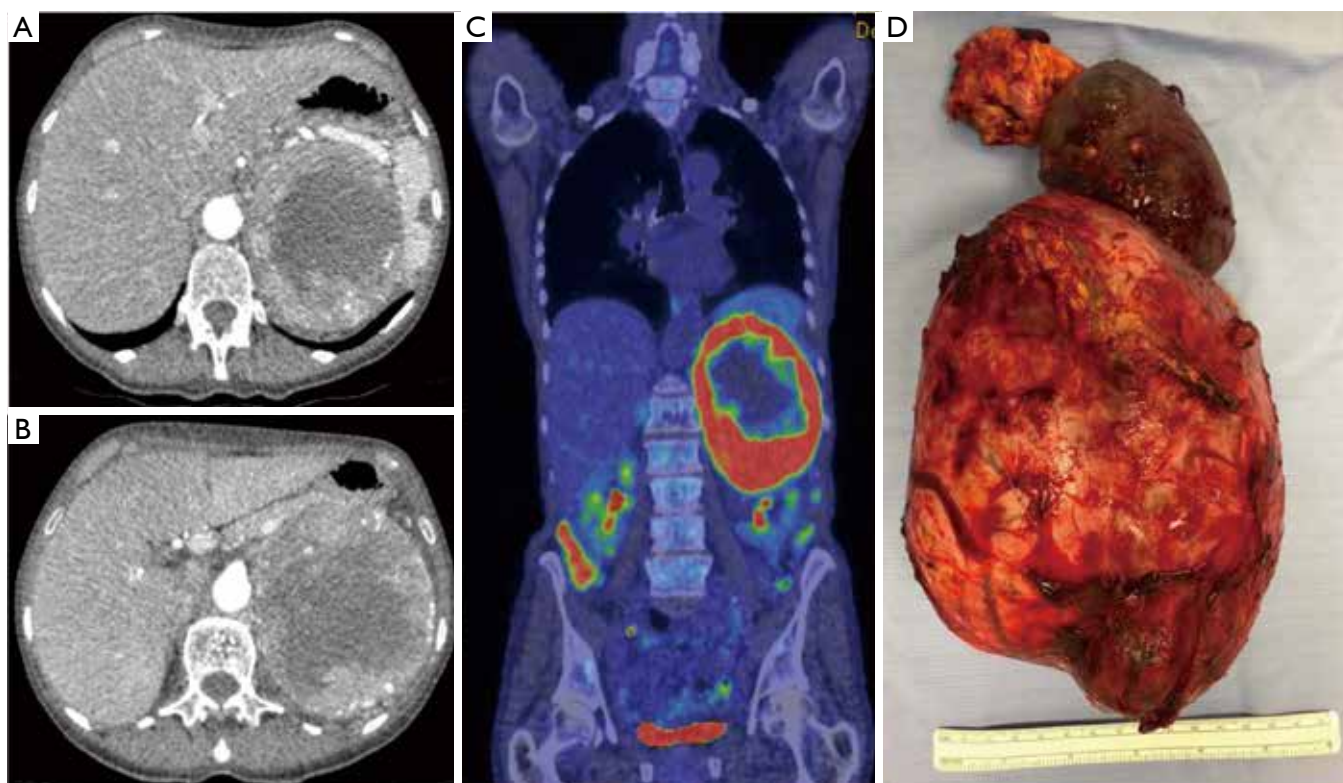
Left-sided adrenalectomy for adrenocortical cancer. Patient with non-functional ACC identified during cross sectional imaging for respiratory complaints. CT scan shows splenic artery stretched over the top the tumour (A) and tail of the pancreas in extensive contact with the tumour (B). PET scan showed no local lymphadenopathy (C). Tumour was resected intact together with the spleen and tail of pancreas (D). ACC, adrenocortical cancer.
